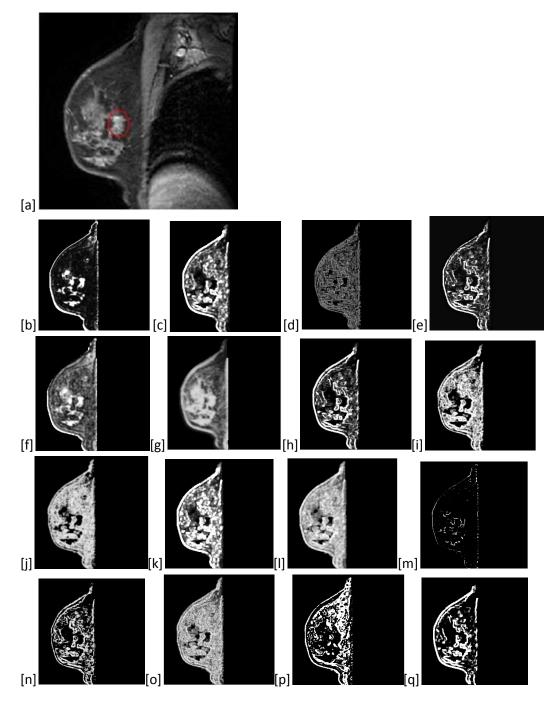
original MR image [a] acquired at 2 minute post contrast using a high resolution 3D T_1 weighted sequence. Patient is a 51 year old female with a benign lesion (highlighted after visual inspection and reference to radiological report). Radiologist report stated the lesion as having poorly defined margin with surrounding normal parenchyma, biopsy result revealed mild duct ectusia in the right breast. Maps were generated post segmentation of original MR image using the in house software's texture mapping feature, the maps [b-q] are of texture parameters f_1 to f_{16} respectively using a 5x5 matrix size
